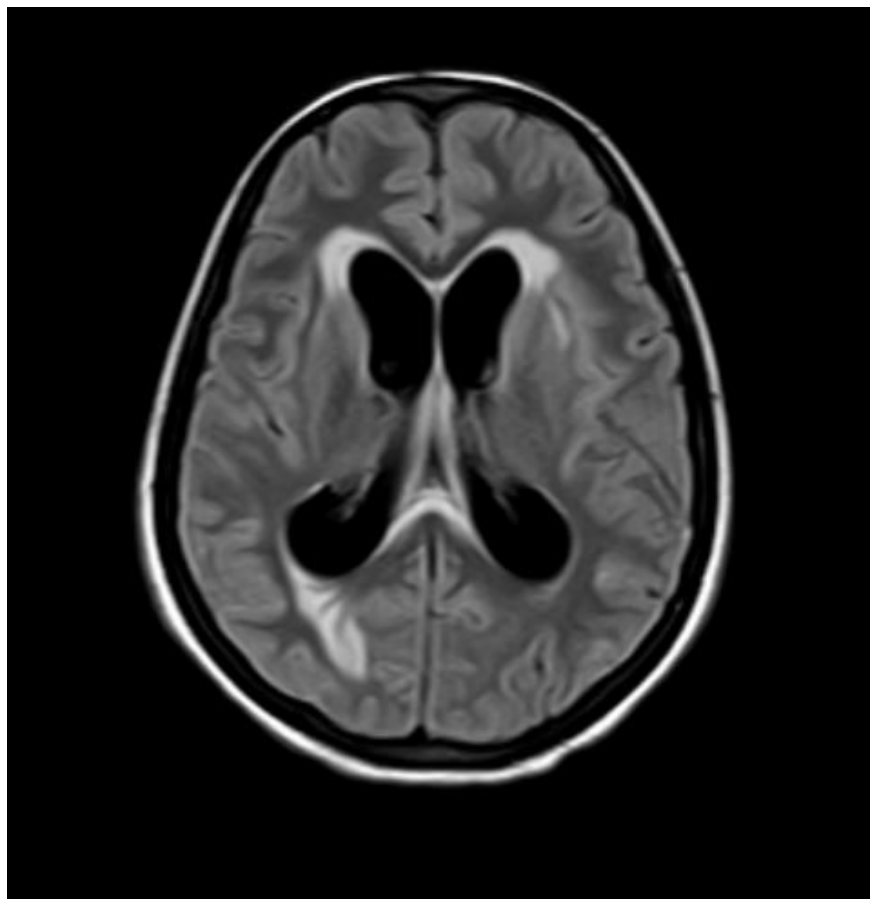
FLAIR (Fluid Attenuated Inverse Recovery) showing dilatation of the ventricular system with periventricular ooze suggestive of hydrocephalus
